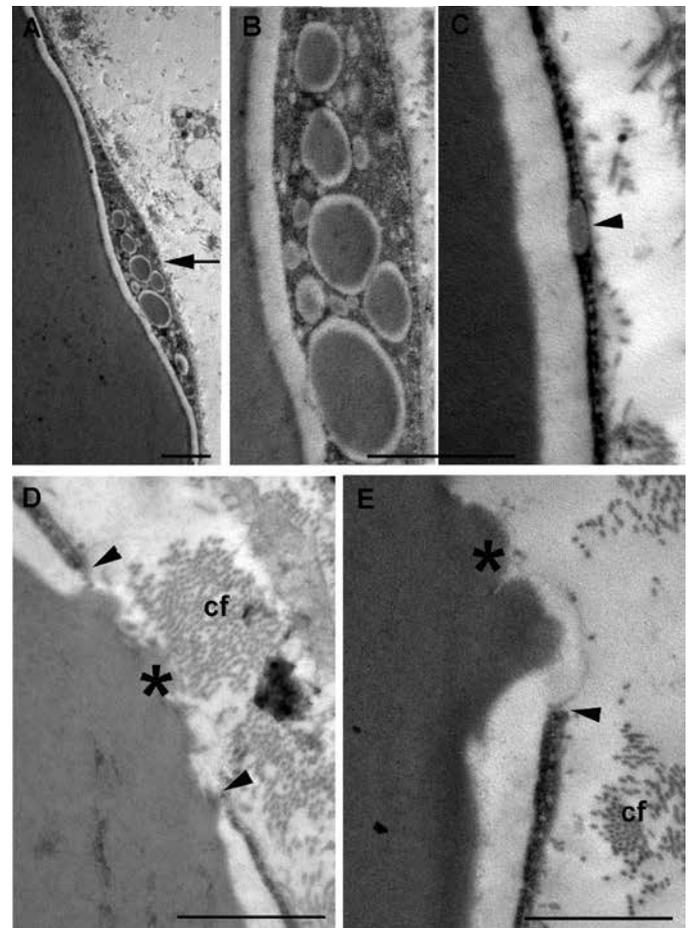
Representative TEM images of adipose tissue from ex vivo skin explants subjected to ultrasound treatment by Med2Contour
